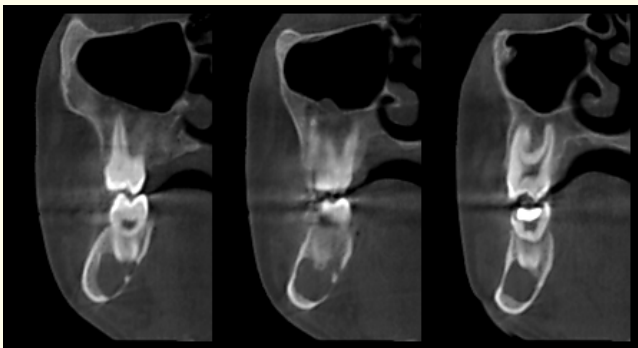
Advanced imaging by CBCT appreciating the changes.
